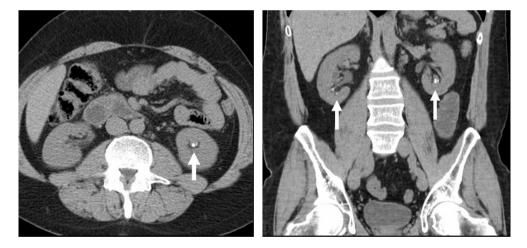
Non-contrast CT demonstrating multiple bilateral renal calculi (arrows), which can be obscured on contrastenhanced images, particularly delayed images when there is excreted contrast in the renal collecting system; axial left, coronal reformat on right.
